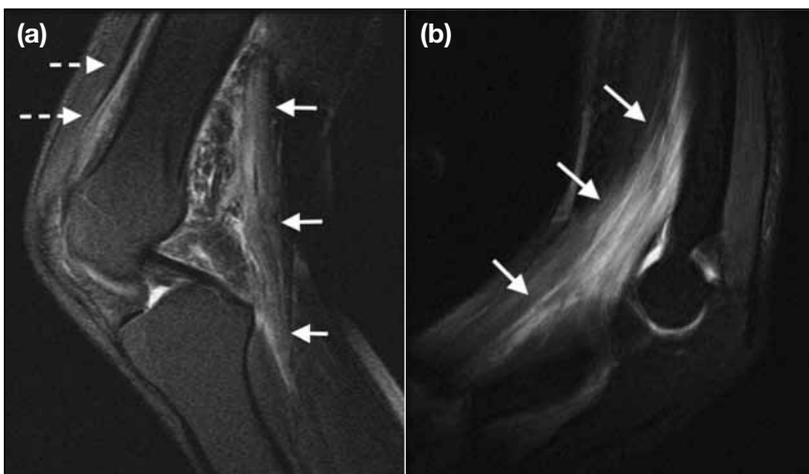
Fat-suppressed T2-weighted magnetic resonance imaging of both knees and elbows shows T2 hyperintensities within the flexor muscles with symmetrical involvement. (a) Abnormal T2 hyperintensities in the flexor compartment in the knees (white arrows), including bilateral hamstrings, semi-tendinosus, semi-membranosus, and heads of gastrocnemius in the knees. Mild quadriceps thinning is also noted (broken arrows). (b) Involved muscles in the elbows are also in the flexor compartment, including the bilateral brachialis (white arrows).
